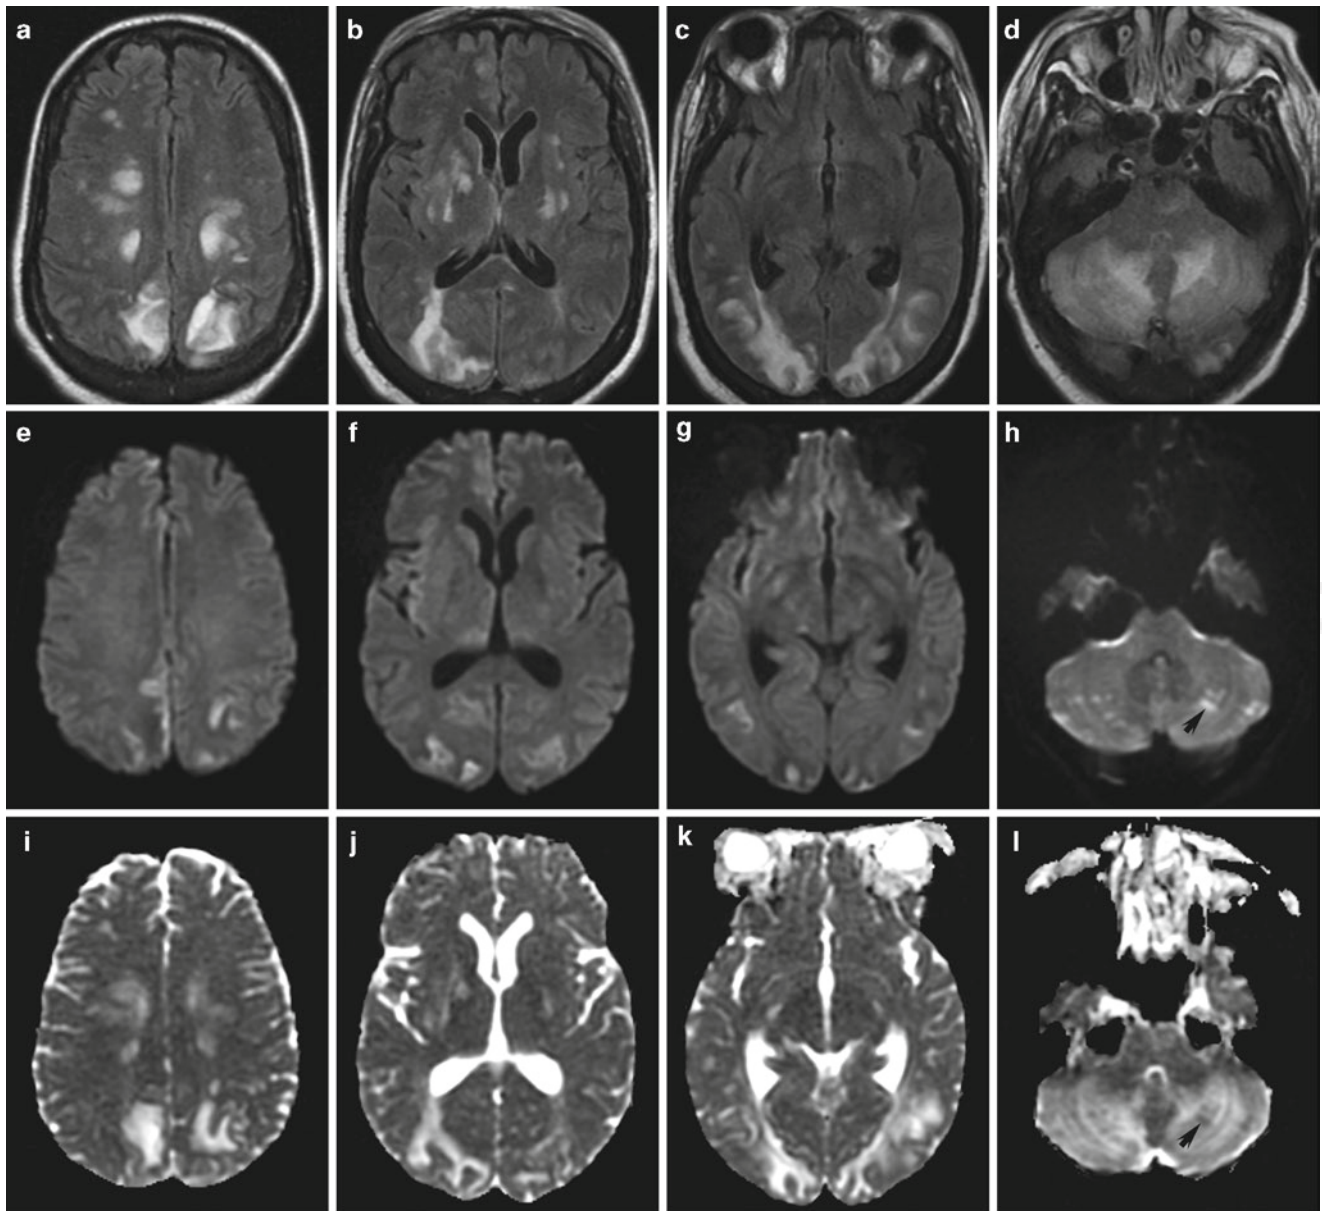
PRES. (a–d) Axial FLAIR images demonstrate extensive patchy FLAIR hyperintensity involving the supratentorial cortex and subcortical white matter, deep gray and white matter, and the cerebellum. Many of the lesions are in a border zone distribution and are indistinguishable from subacute infarctions on FLAIR images. (e–h) The lesions are of mixed intensity on DWI, but (i–l) predominantly
